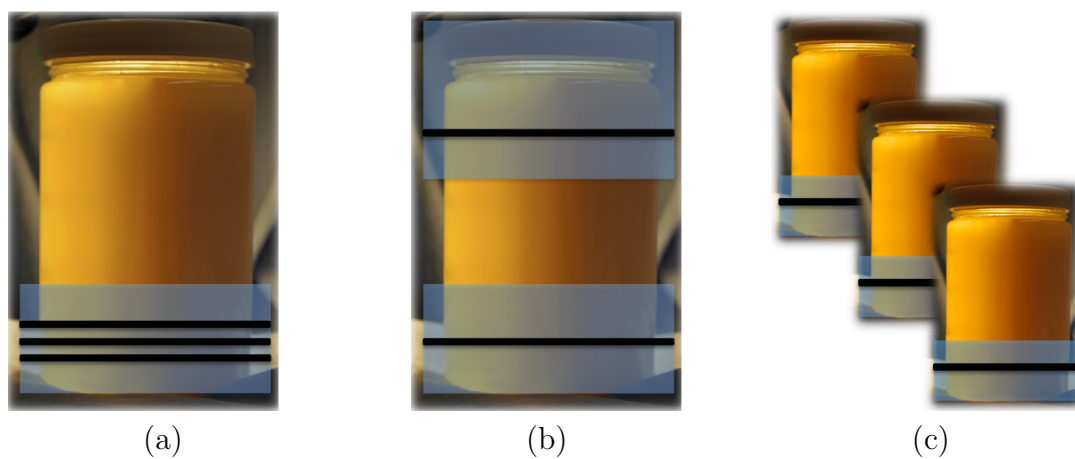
Regions of irradiated gel (shaded blue) and the corresponding CT imaging locations (solid black lines) for the (a) local intra-batch reproducibility study, (b) global intra-batch and dose rate studies and (c) inter-batch reproducibility study.
